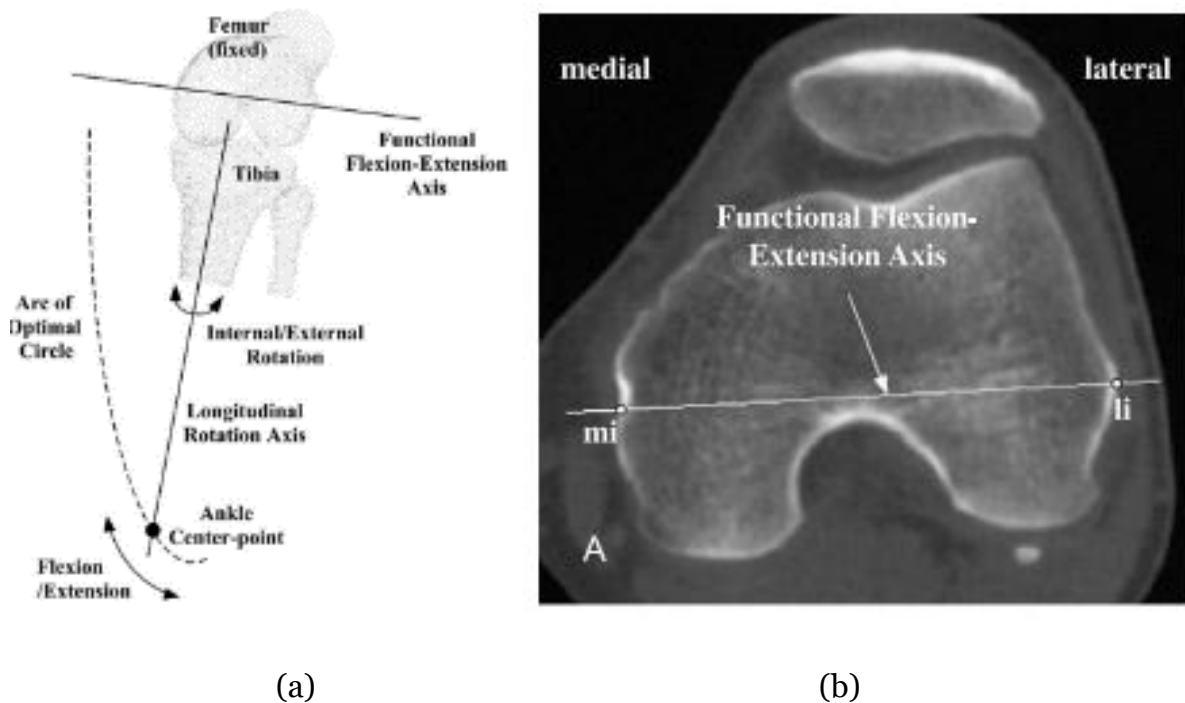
(a) The functional flexion-extension axis shown (a) on an anterior view of a left leg during knee flexion; and (b) in a transverse plane CT-scan on a right leg. (Asano et al., 2005 – reprinted with permission from Elsevier)
